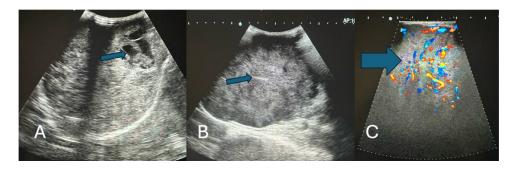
Grey scale B mode ultrasound image shows an ill defined heterogeneously hypoechoic mass lesion (A) was identified within the subcutaneous tissues of the medial aspect of the left arm with few cystic and calcific areas (A, B). The lesion was taking vascularity on Doppler and was suggestive of a soft tissue tumor (C).
